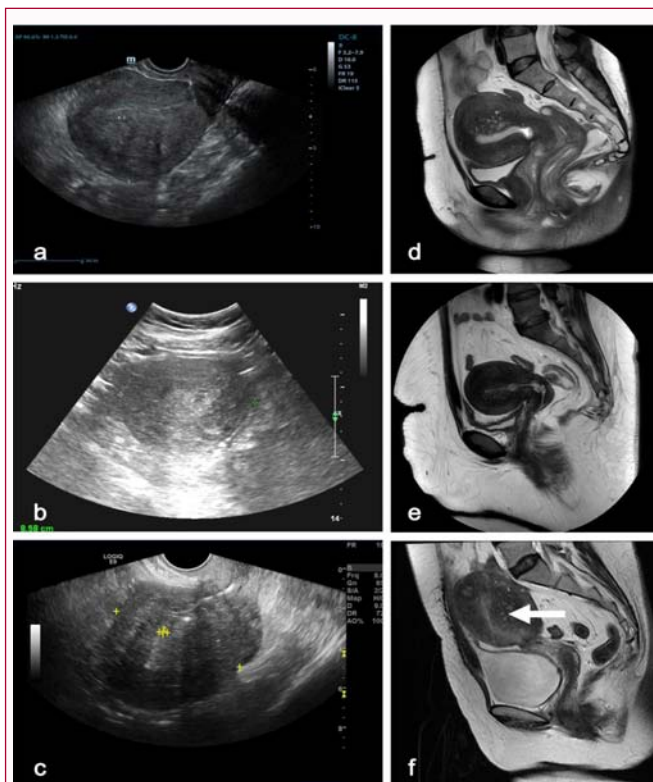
Ultrasound and MRI images for asymmetrical intrinsic adenomyosis in refractory abnormal uterine bleeding.
